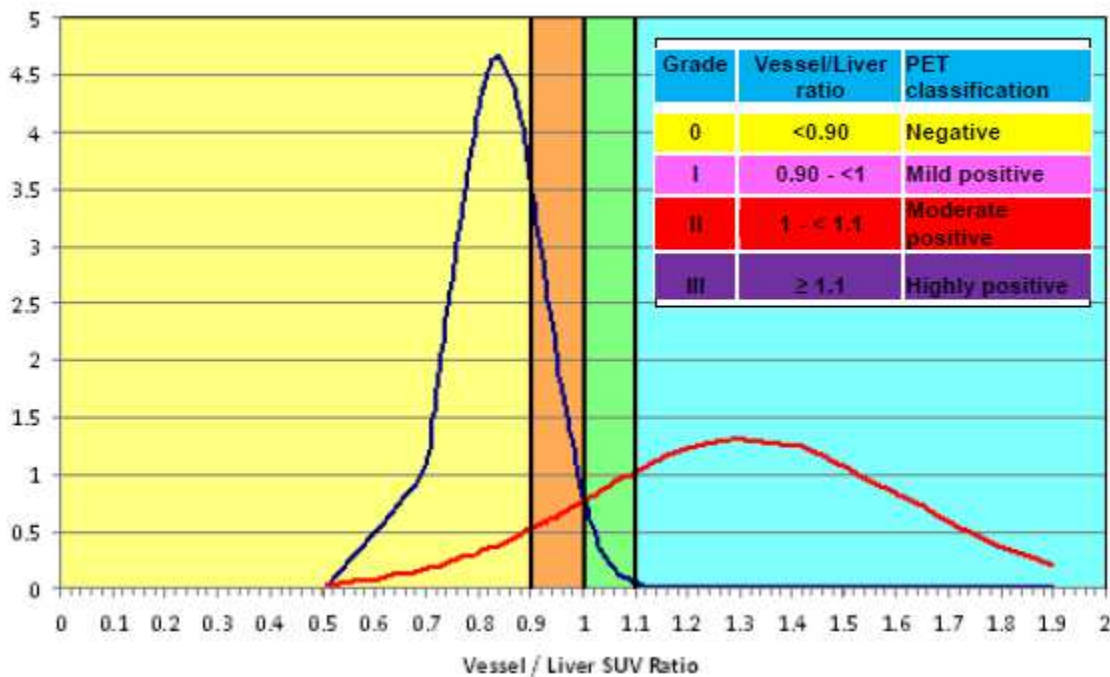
Normal distribution of SUVmax vessel/liver ratio; a semiquantitative analysis on (vessel SUV max)/(liver SUV max) was performed to rate the disease into a 4-step system
